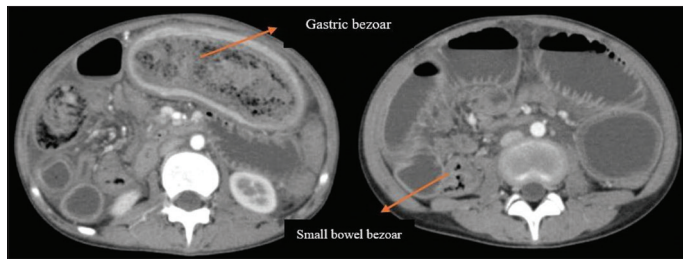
Contrast-enhanced computed tomography imaging demonstrating gastric and small bowel bezoar
